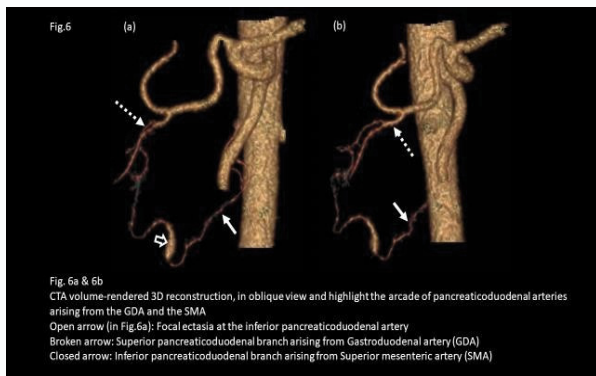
CTA volume-rendered 3D reconstruction, in oblique view and highlight the arcade of pancreaticoduodenal arteries arising from the GDA and the SMA.
